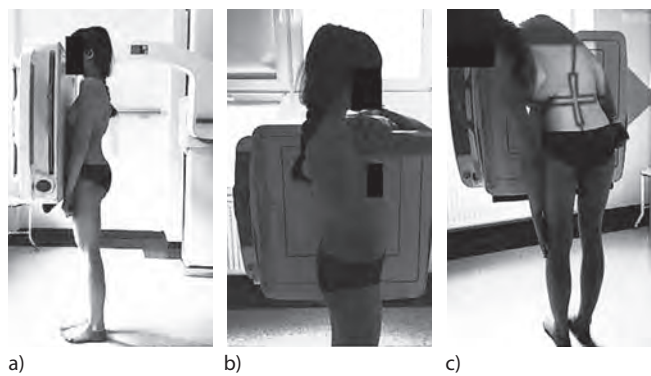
Preoperative radiological examination technique: a) standing posteroanterior, b) lateral radiographs, c) both side bending on postero – anterior radiographs, d) traction radiographs in supine position
